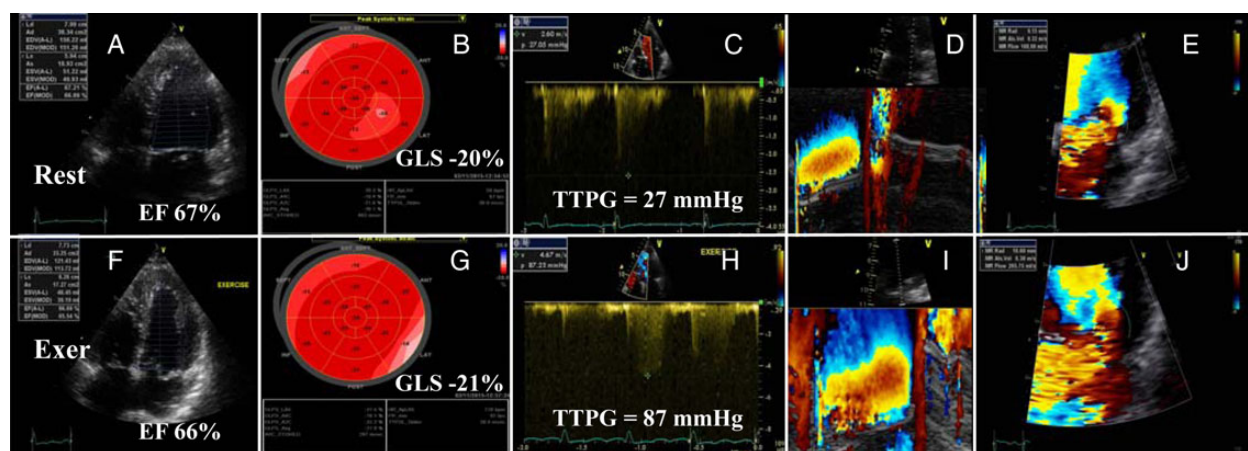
Patient with mitral valve prolapse and mitral regurgitation. (A–E) Rest evaluation; (F–J) exercise echocardiography results. At rest, left ventricular function was normal (EF 67% and global longitudinal strain [GLS] -21%). During exercise, EF and GLS did not change significantly, indicating no contractile reserve. Conversely, the systolic PAP (transtricuspid pressure gradient [TTPG]) (HC) and the severity of mitral regurgitation (DEI) increased severely. (D and I) The M-mode of the flow convergence zone and (E and J) the PISA radius at rest and at exercise using color flow imaging. It should be noted that the mitral regurgitation flow is very eccentric in this example; PISA is less reliable in this circumstance.
